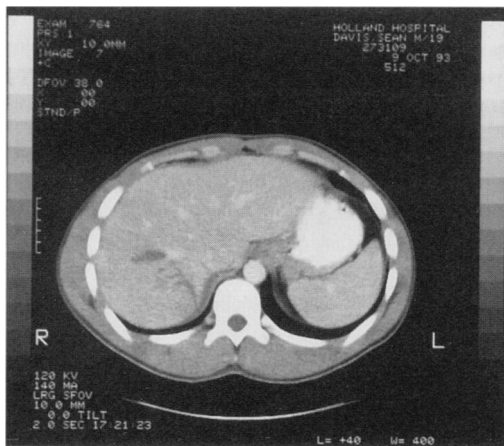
CT scan 60 minutes postinjury. Note decreased density in curvilinear pattern in right lobe of the liver indicative of liver laceration.
